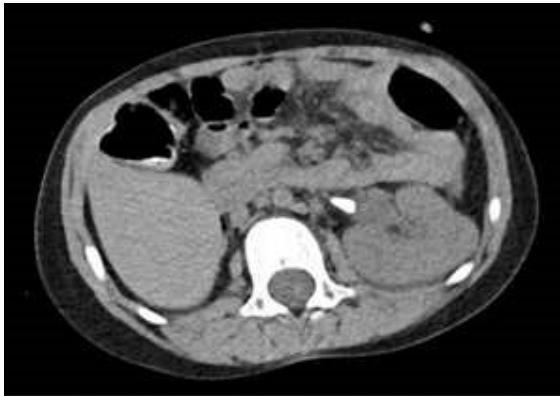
Axial CT scan showing proximal obstructing left ureteral stone measuring 1.0 cm.
